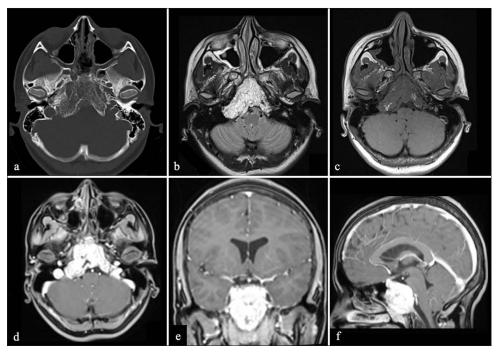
Neuro-imaging findings at diagnosis. (a) Axial bone Computerized Tomography (b) Brain magnetic resonance imaging (MRI): Axial T2 (c) Brain MRI: Axial T1 without contrast (d) Brain MRI: Axial T1 with Gadolinium (e) Brain MRI: Coronal T1 with Gadolinium (f) Brain MRI: Sagittal T1 with Gadolinium.
